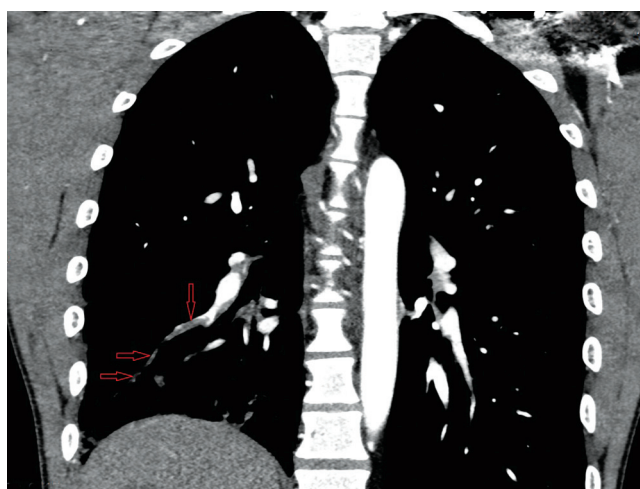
CT signs of pulmonary embolism in segmental branches of the right pulmonary artery – non-occlusive thrombosis of S8 and S9 segmental branches of the right pulmonary artery. The blood clots indicated by arrows
